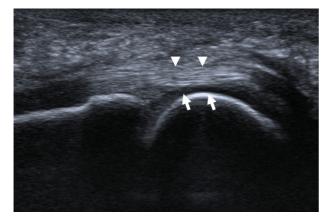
Sagittal ultrasound image demonstrating an extensive full-thickness tear of the plantar plate of the second MTP joint with retraction and resultant direct abutment between the flexor tendon (arrowheads) and second metatarsal head articular cartilage (short arrows).
